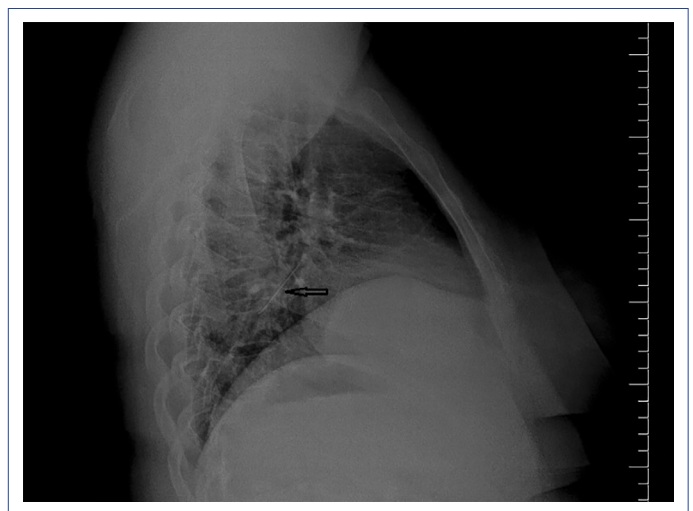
Lateral chest X-ray image of a pin aspiration case.
